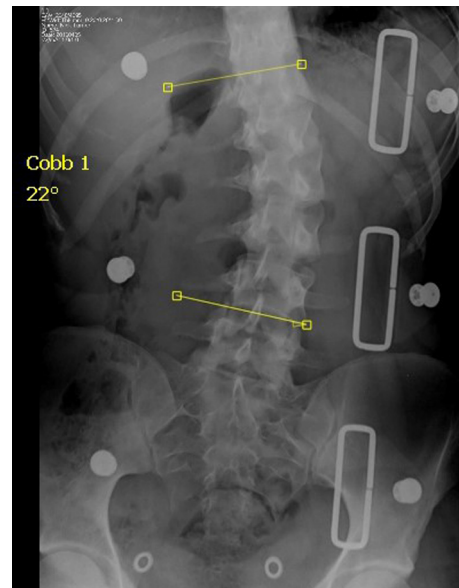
In-brace AP radiograph.
